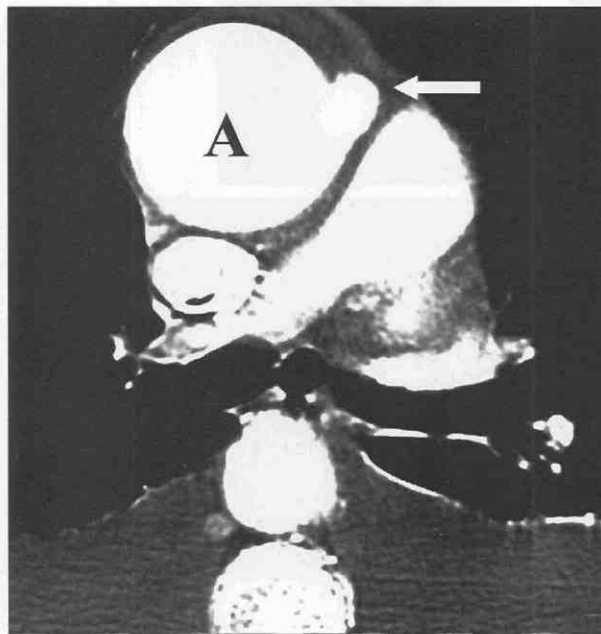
Axial CT scan shows an aneurysm in the ascending aorta with an active leak (arrow). The patient presented with hemorrhagic pleural effusion and died the next day. A = ascending aorta.
